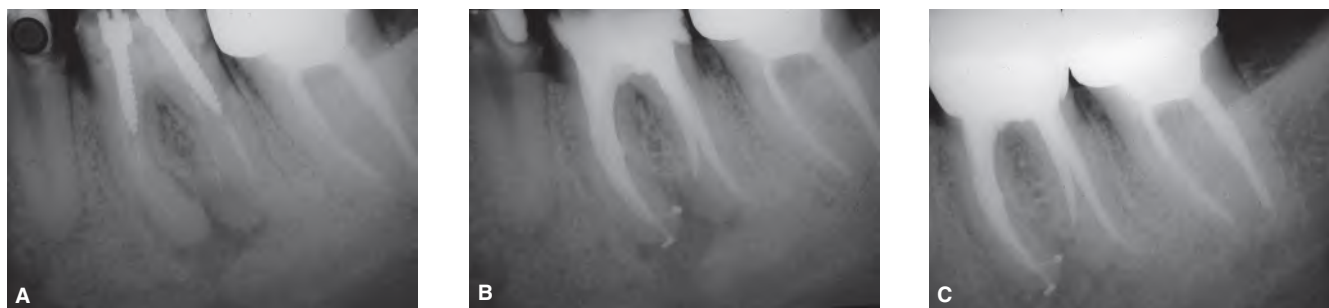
A.* Retreatment was attempted on the first mandibular molar. The preoperative radiograph showed two large screw-posts and a broken separated instrument in the second distal canal. *B.* The separated instrument was removed but negotiation of the canal terminus was unsuccessful. A wait and see approach was adopted. *C.* Despite a less than ideal result, a one-year recall radiograph showing evidence of ongoing healing.
